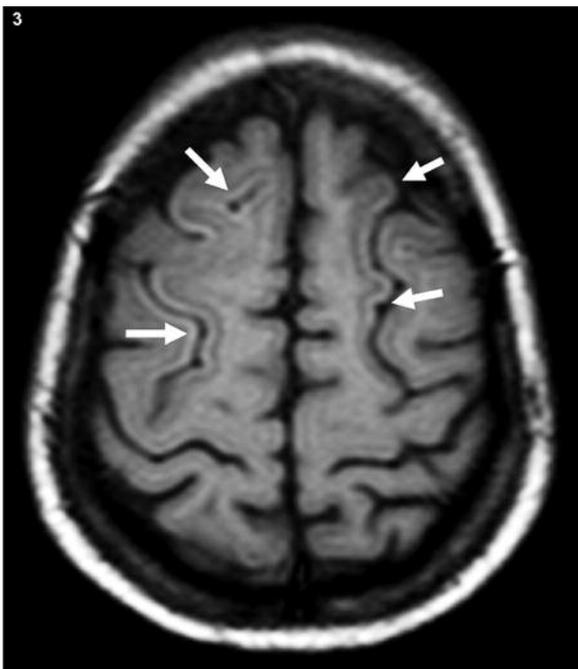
In the first month control MRI, on T1-weighted series, subacute hemorrhage products in hyperintense areas which showed gyral-pattern linear distribution were seen.
